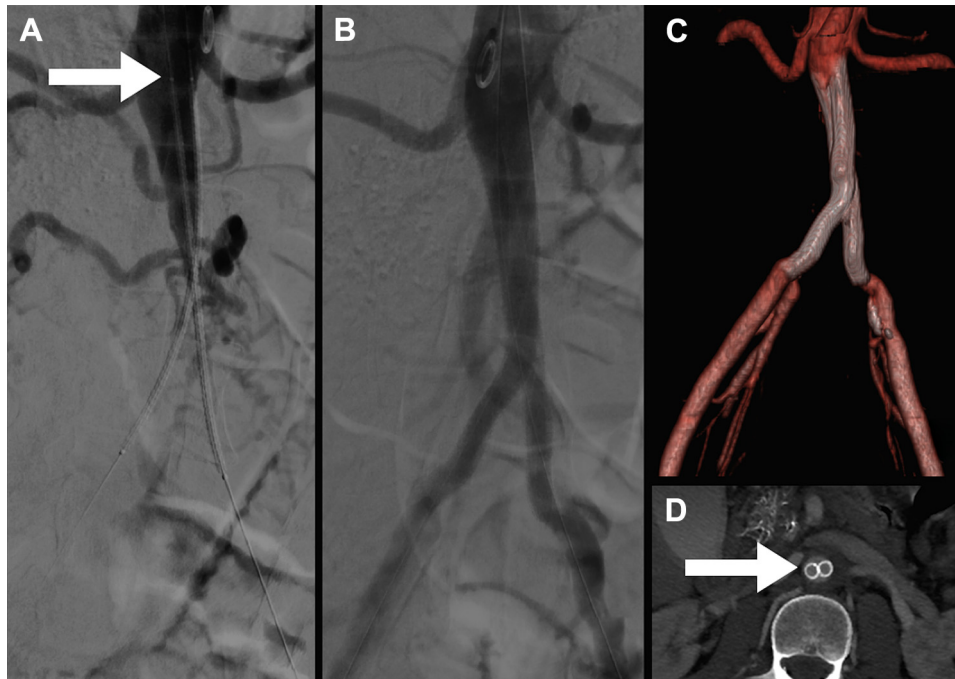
A, Proximal edge of two Viabahn (W. L. Gore and Assoc, Flagstaff, Ariz) covered stents (*arrow*) positioned immediately inferior to the renal arteries. B, Completion angiography after endovascular recanalization (EVR). C, A three-dimensional computed tomography scan reconstruction after 6 months from the procedure shows a good result of the procedure. D, Computed tomography image shows the proximal position of the two Viabahn covered stents (*arrow*).
